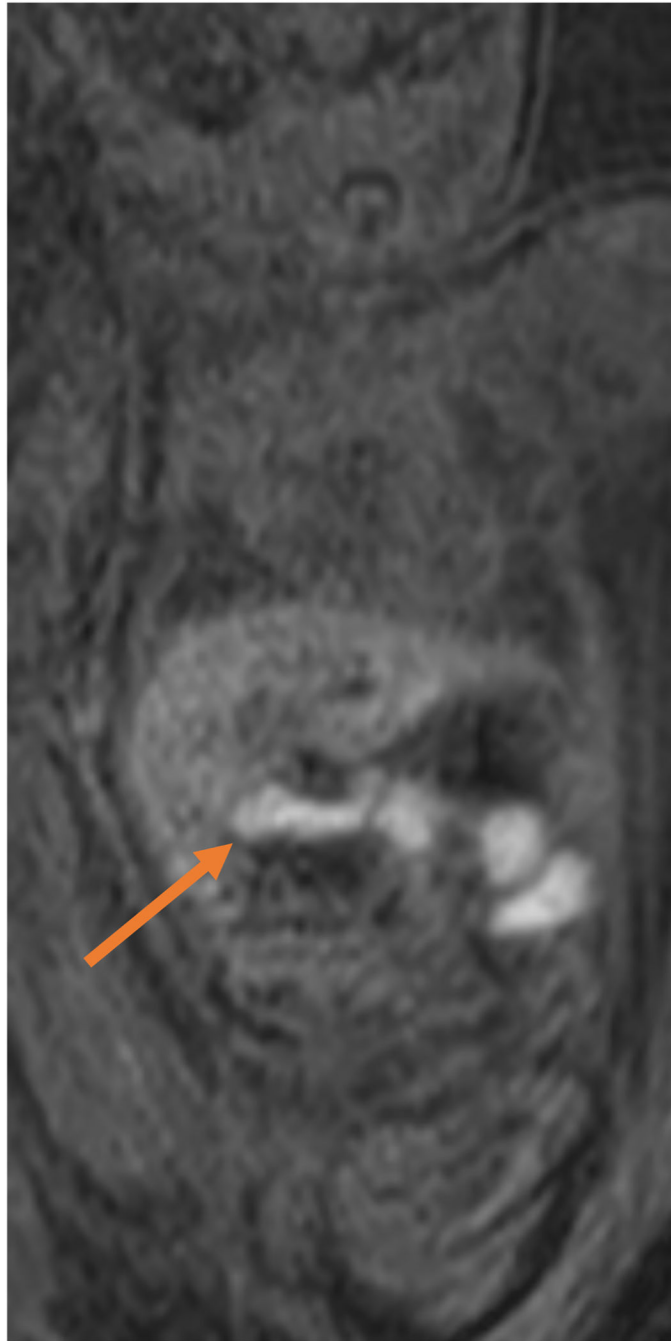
Coronal T1 weighted with fat saturation fetal MR image at 33 weeks, 4 days demonstrate a right upper quadrant position of the cecum (arrow).
